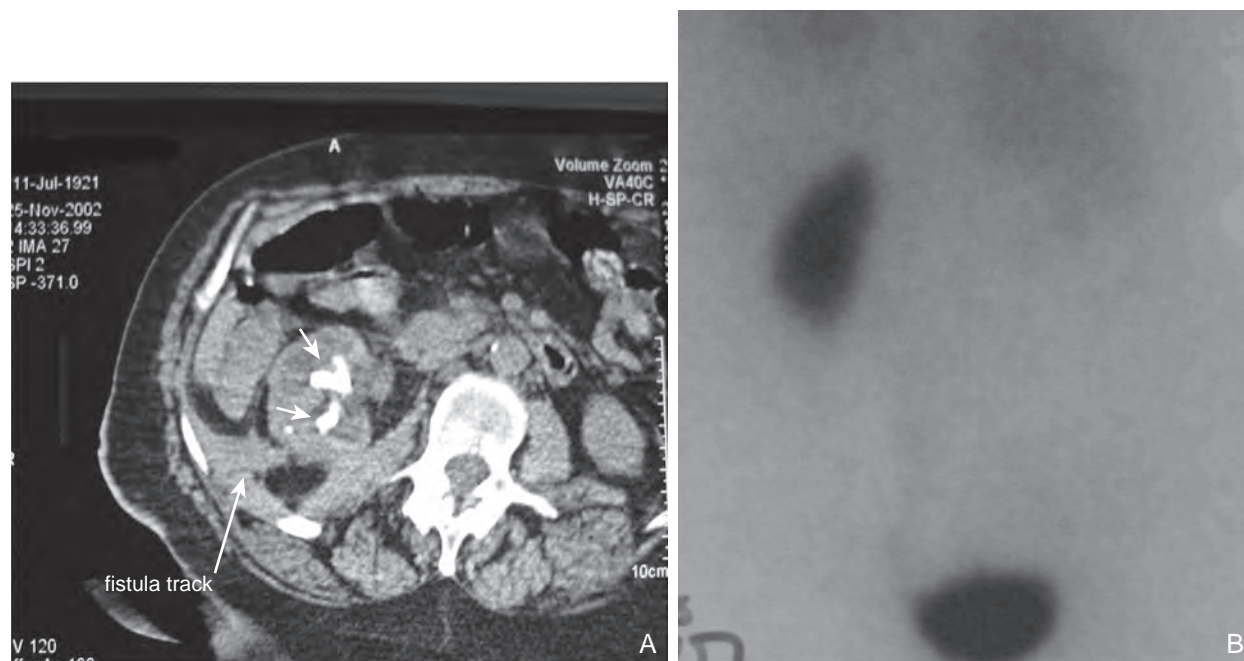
A, Computed tomography image of a staghorn calculus within the right kidney. Arrow points to a fistula that spontaneously eroded through the triangle of Petit. This patient denied a history of recurrent urinary tract infections. B, Nuclear renogram of the same patient as in A. Note the complete lack of function of the affected kidney. This organ was removed laparoscopically.
